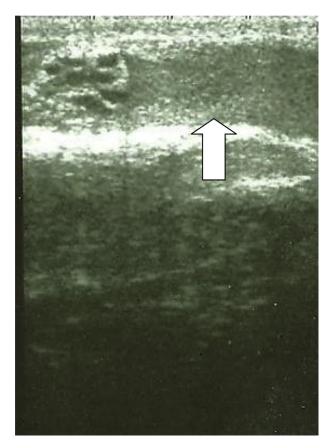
Ultrasound showed a large hematoma of the spermatic cord (arrow) plus varicocele (hypoechoic area).
